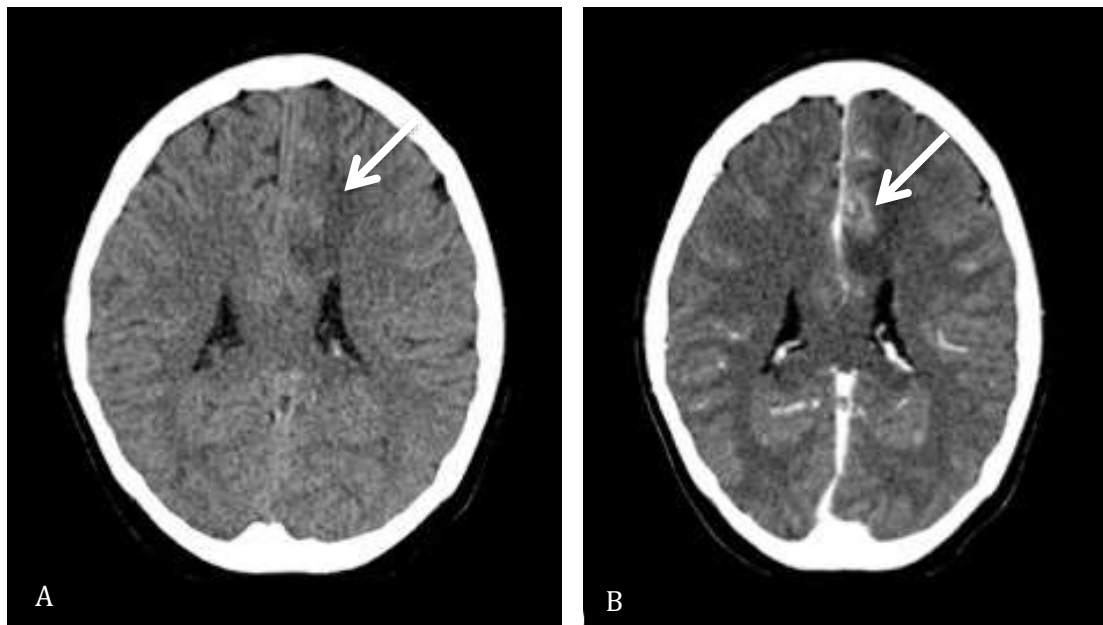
Case 1; 14yo/girl. (A) Non-enhanced CT brain shows an ill-defined white matter oedema in the parasagittal region of the left frontal region (arrow). (B) On post-contrast CT, there is a rim-enhancing lesion at this region on contrasted CT brain (arrow).
